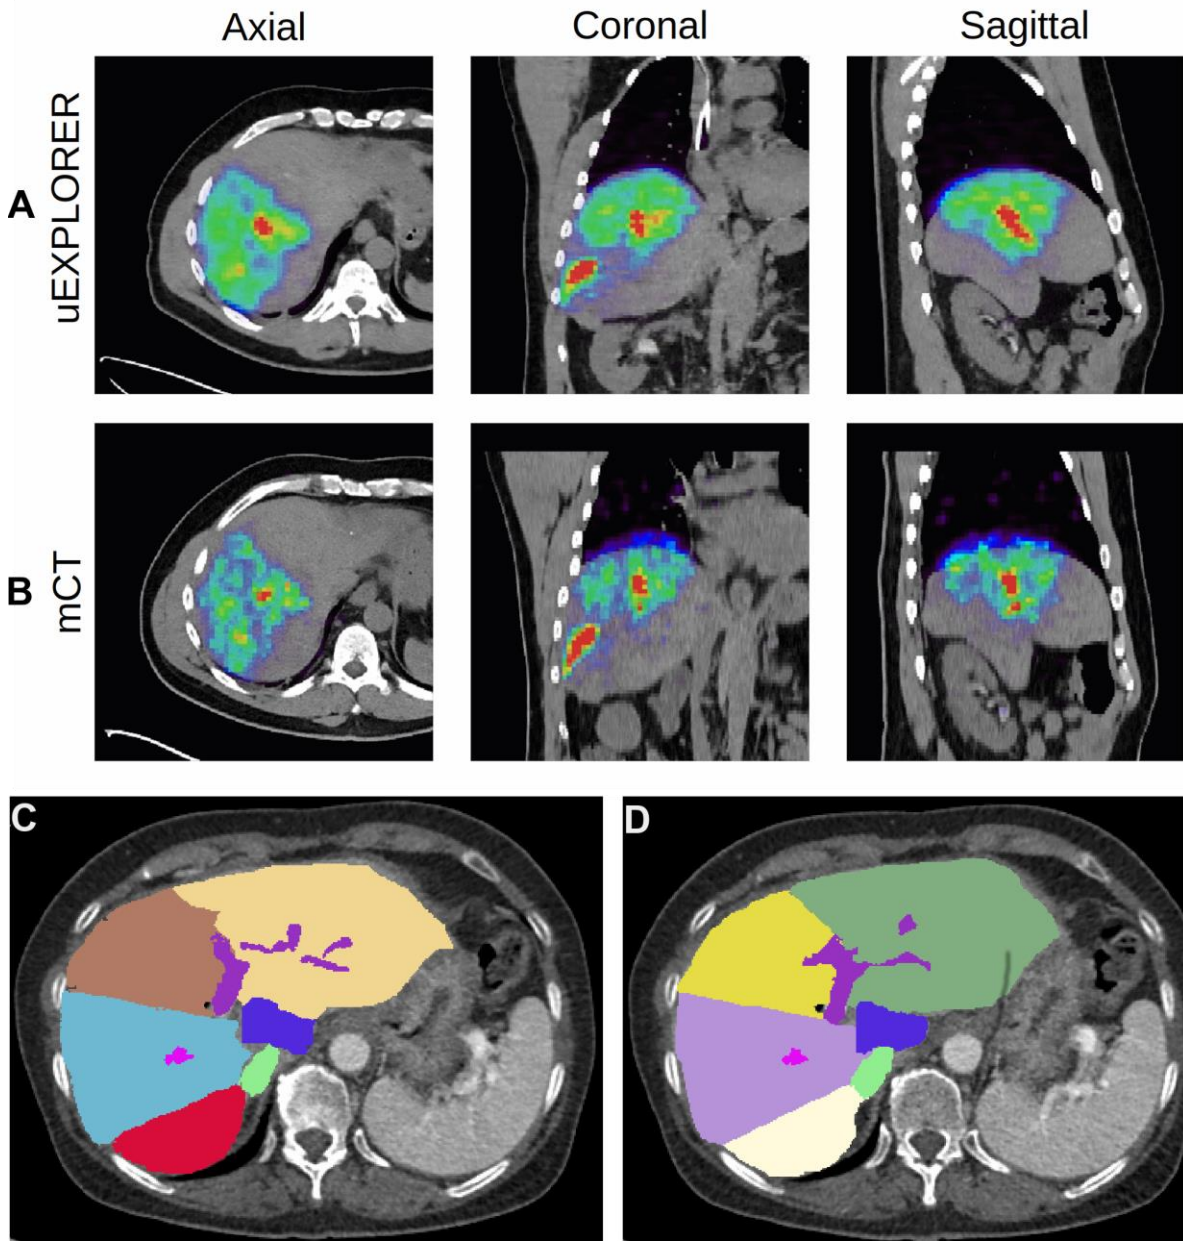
Patient images of PET/CT at axial, coronal and sagittal views from the (A) uEXPLORER and (B) mCT. The uEXPLORER images without smoothing are less noisy than the mCT and additional smoothing to the uEXPLORER. And the CECT at axial view with Couinaud segments at the (C) upper liver containing segments 2, 4a, 7 and 8 and (D) bottom liver containing segments 3, 4b, 5 and 6. IVC, LPV and RPV can be visualized in both upper and bottom liver.
